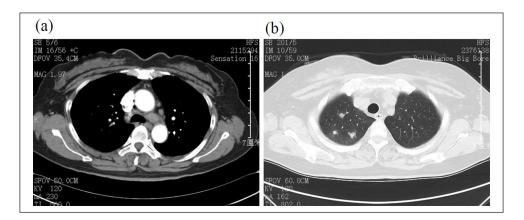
(a) CT scan revealed mediastinal multiple lymphadenopathy. (b) Multiple small nodules in the upper right lobe.
